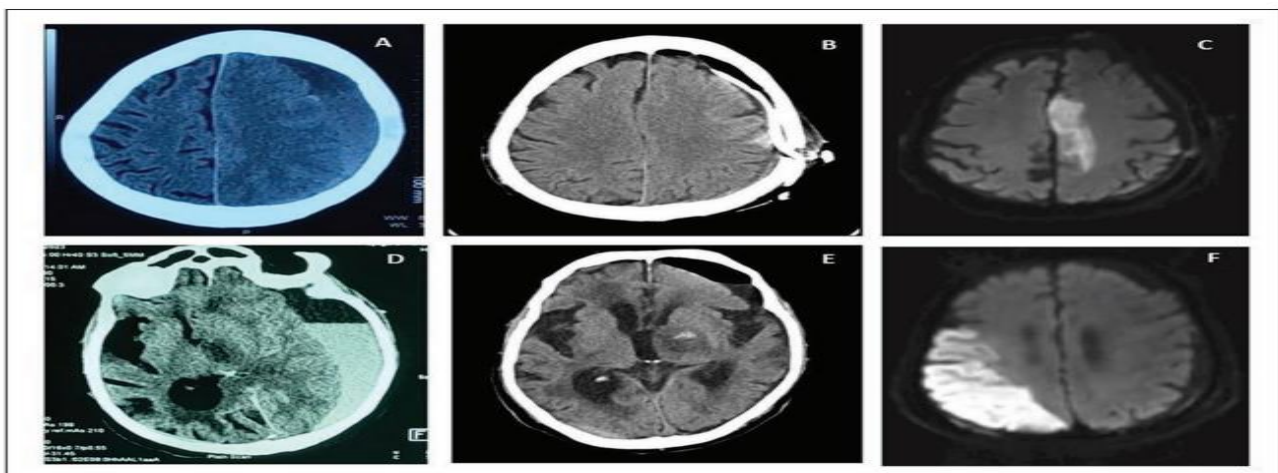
(A) First Case Non-Contrast CT Scan showing Left-sided CSDH and Midline Shift. (B) Post-operative Non-Contrast CT Scan Demonstrating the Removal of the Haematoma with an Installed Subdural Drain. (C) DWI Sequence Demonstrating Diffusion Restriction in Left Anterior Cerebral Artery Territory Indicative of an Infarct. (D) The second case's non-contrast CT scan revealed left-sided CSDH and a hypodense area in the left thalamus. (E) Post-operative Non-Contrast CT Scan Displaying Haematoma Evacuation and Hemorrhagic Thalamic Infarct. (F) A DWI Sequence Showing Diffusion Restriction Along the Right Middle Cerebral Artery's Inferior Division Suggestion of Infarct
